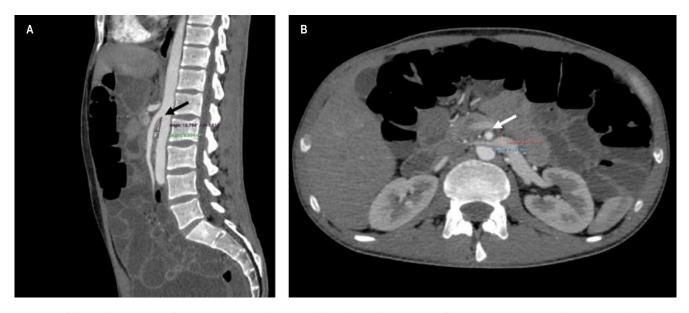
Abdominal CT scan. A. The reconstruction in the sagittal plane shows the narrowing of the aorto-mesenteric angle, 12,786°, with a reduced aorto-mesenteric length of 5334 mm (black arrow). B. The reconstruction in the axial plane shows the compression of the left renal vein with a ratio of the anteroposterior diameter of the compressed vein over the enlarged compressed vein (6927 mm/2179 mm = 1179) (white arrow).
